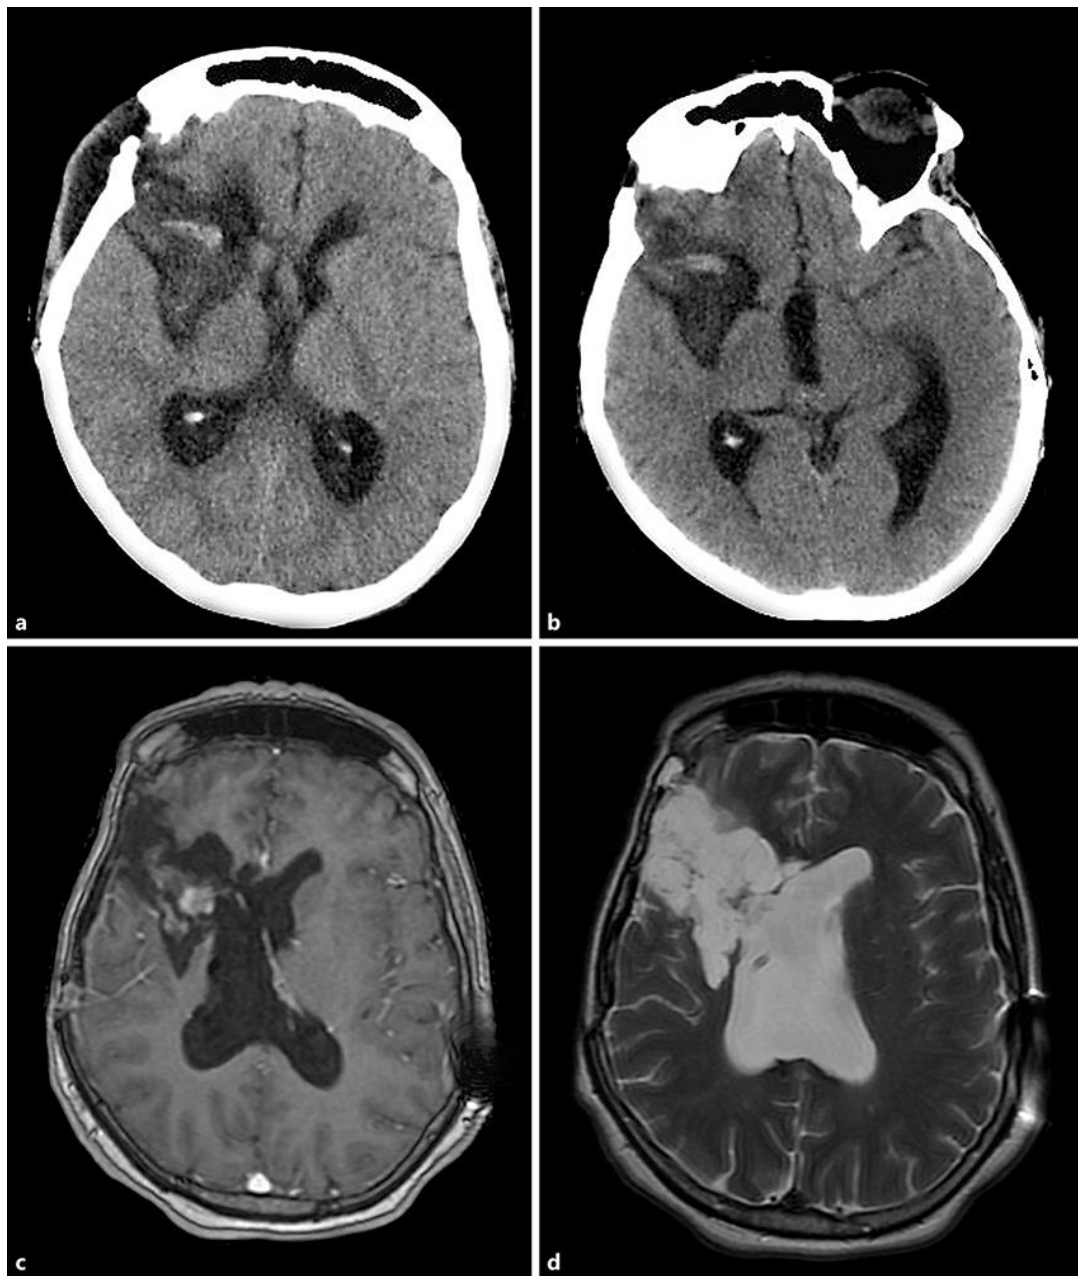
Postoperative axial CT scan (a) shows a hyperdense mass lesion in the surgical cavity. A follow-up brain CT scan 20 days after surgery (b) shows persistence of the hyperdense mass lesion. Postoperative axial gadolinium-enhanced T1-weighted (c) and axial T2-weighted (d) MRI show enhancement of the textiloma.
